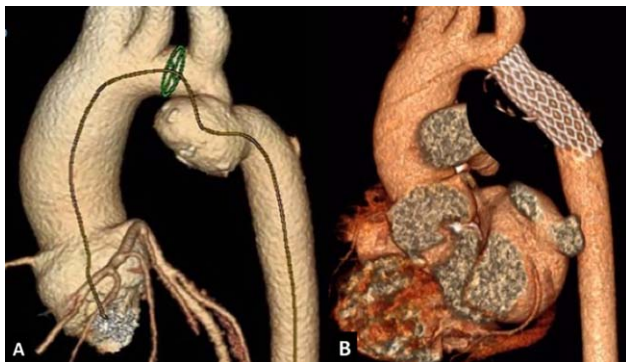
Treatment of postoperative coarctation with associated pseudo aneurysm with the Optimus stent. (A) Neonatal coarctation repair presenting in adulthood with restenosis and aneurysm formation. (B) Follow-up CT imaging showing exclusion of the aneurysm and resolution of the restenosis with uniform expansion of the Optimus stent
